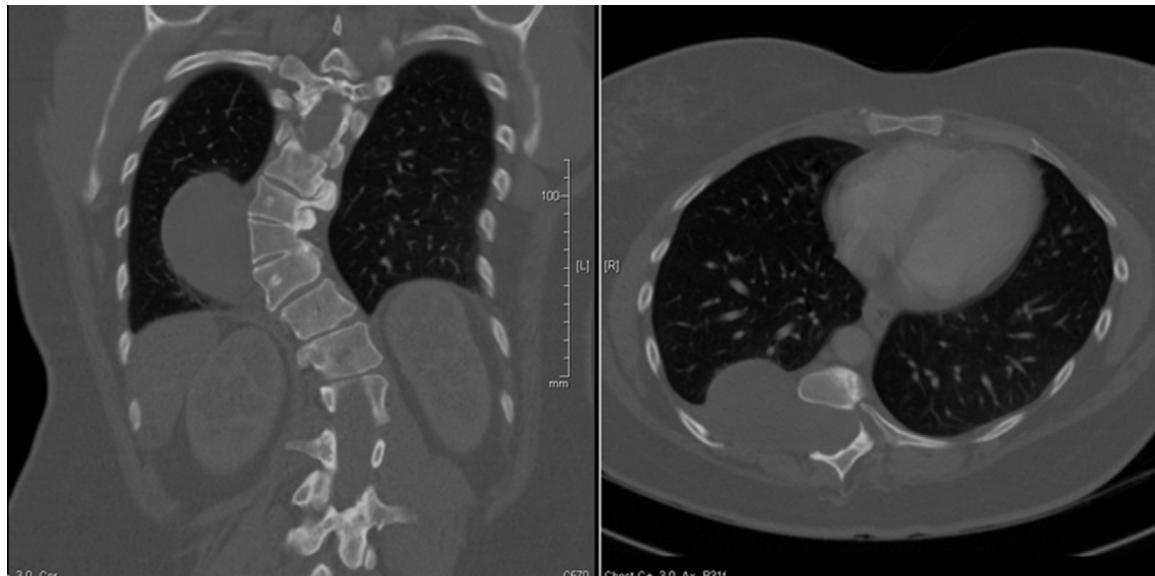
Coronal and axial views of CT chest (bony window) showing a large right paravertebral lesion measuring  $8.3 \times 4.5 \times 7.9$  cm, which appears to be arising from the spine, as evidenced by displacement of right extrapleural fat. Associated scoliosis once again noted.
